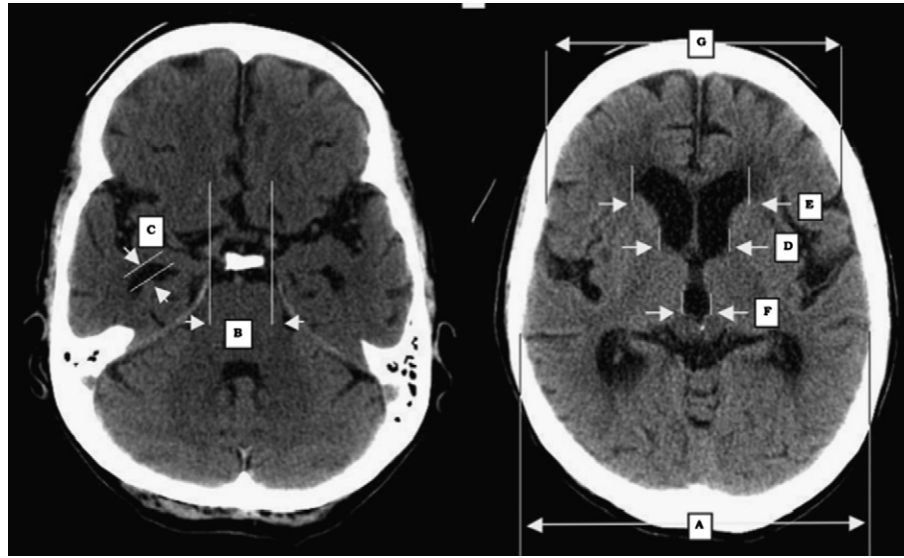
Linear measurements obtained from the axial CT slices. Maximal transversal intracranial width (A), the suprasellar cistern (B), the temporal horn diameter (C), the minimal intercaudate distance (D), the maximal frontal horn width (E), the maximal width of the third ventricle (F) and the maximal width of the frontal skull (G). With those measurements the following indices were calculated (see Table 2); suprasellar cistern ratio (B/A), temporal horn ratio (C/A), bicaudate ratio (D/A), Huckman’s number (D + E), third ventricle ratio (F/A) and Evans ratio (E/G).
